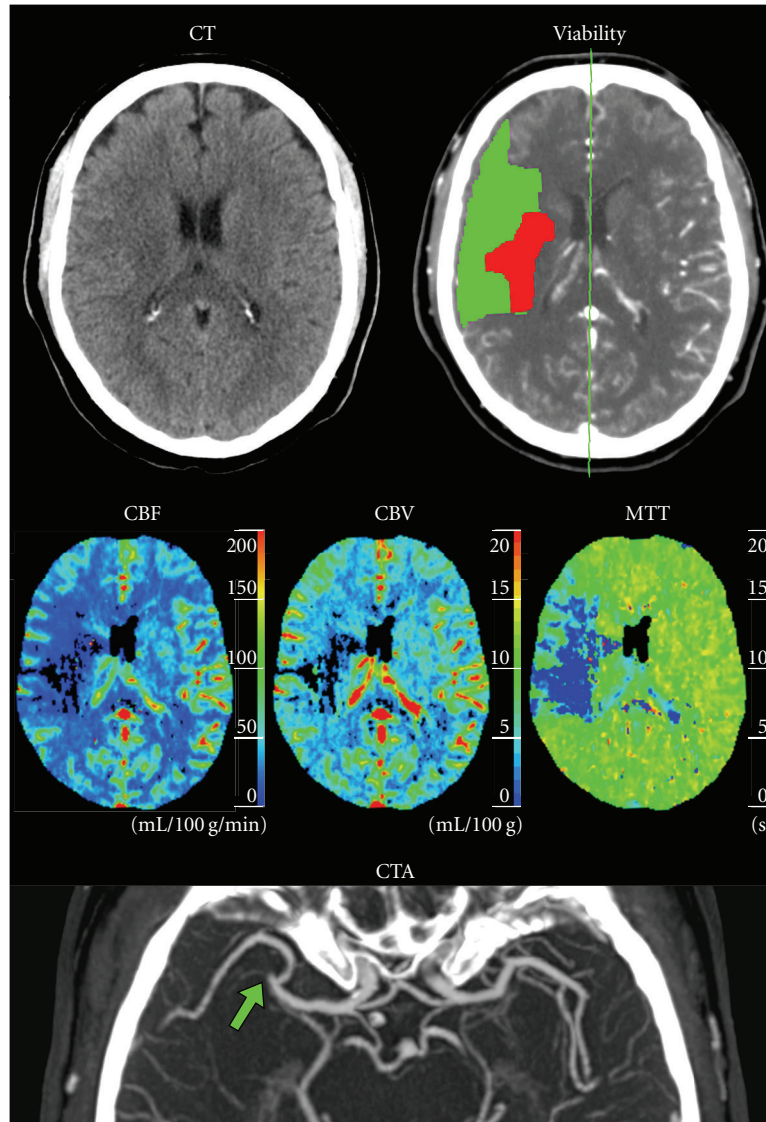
Case 1: 66-year-old male with left-sided stroke symptoms and a normal NECT. Initial comprehensive examination shows reduction of both CBF and CBV in the right hemisphere and an increase in MTT caused by a right-sided M2-segment MCA occlusion (arrow) seen on the CTA. The CTP viability map shows a small area of advanced perfusion defect (red) in the right hemisphere surrounded by a relatively large penumbra (green).
